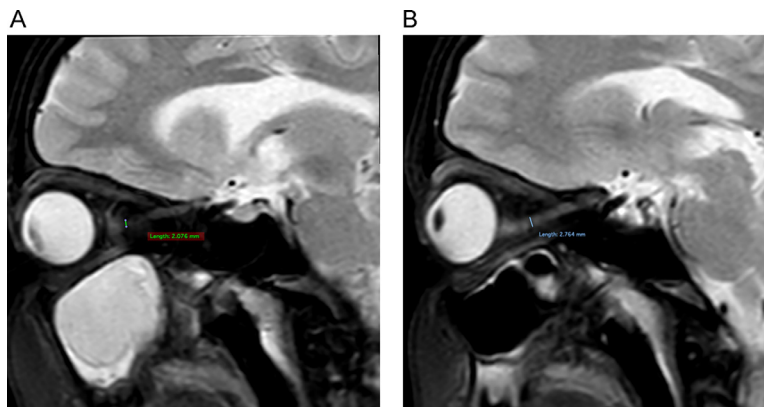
T2 weighted oblique coronal MRI images showing the reduced thickness of the right (A) and left (B) optic nerve sheath.
